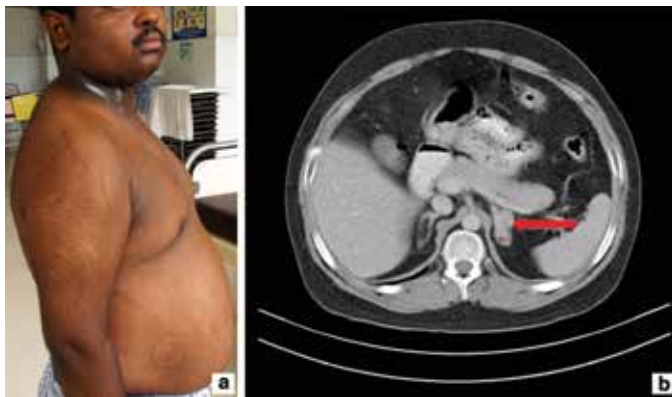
a) Preoperative clinical photograph showing central obesity, hump back and abdominal striae. b) Preoperative abdominal computed tomography scan showing the nodular lesion in left adrenal (red arrow)
